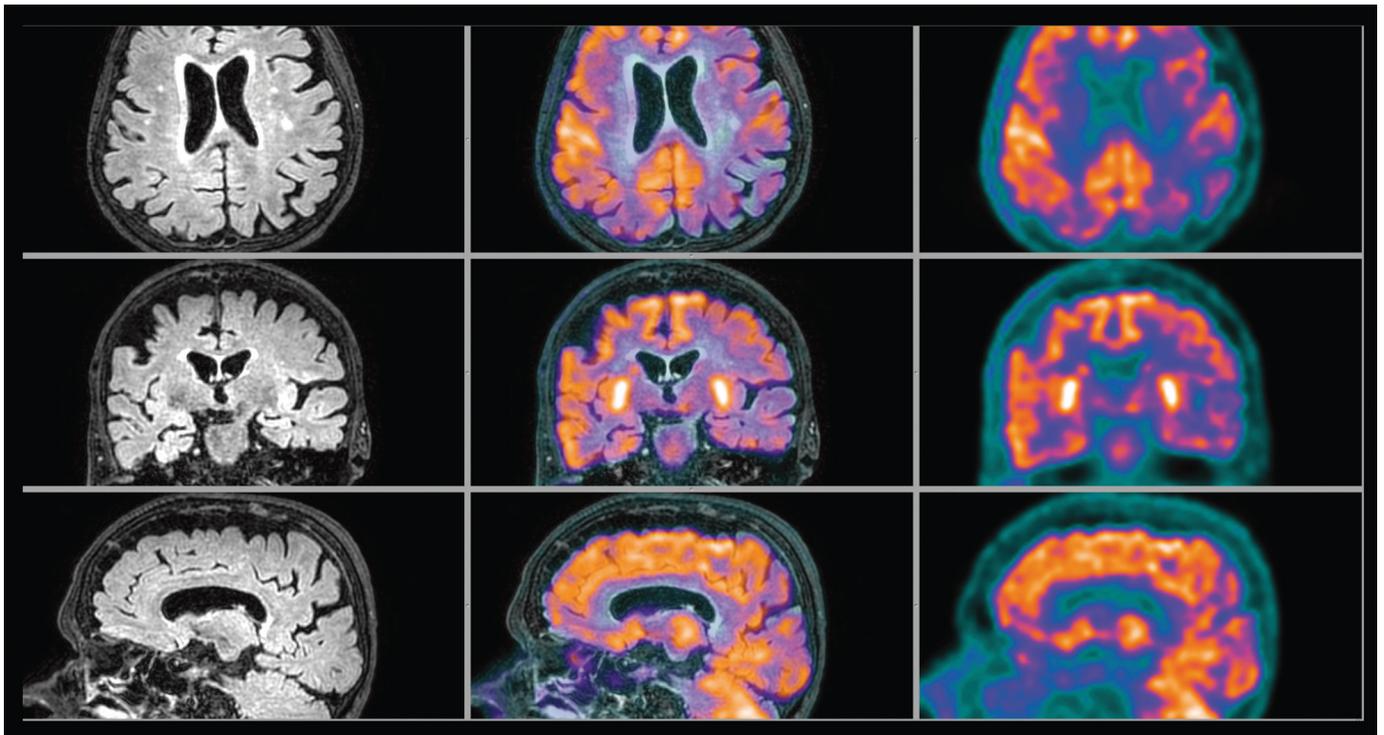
Patient 2: 89-year-old patient with probable Lewy body dementia. MR images show diffuse atrophy, without regional specificity, whereas FDG PET shows a significant posterior cortical hypometabolism, with preservation of posterior cingulate and precuneus metabolism, typically associated with Lewy body dementia.
